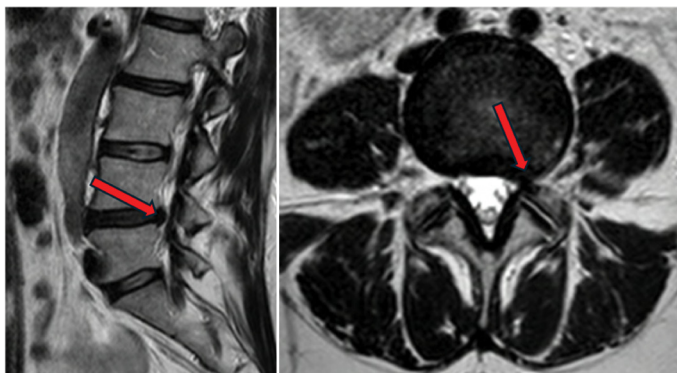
Preoperative MRI showing left L4-L5 foraminal hernia (arrow).
